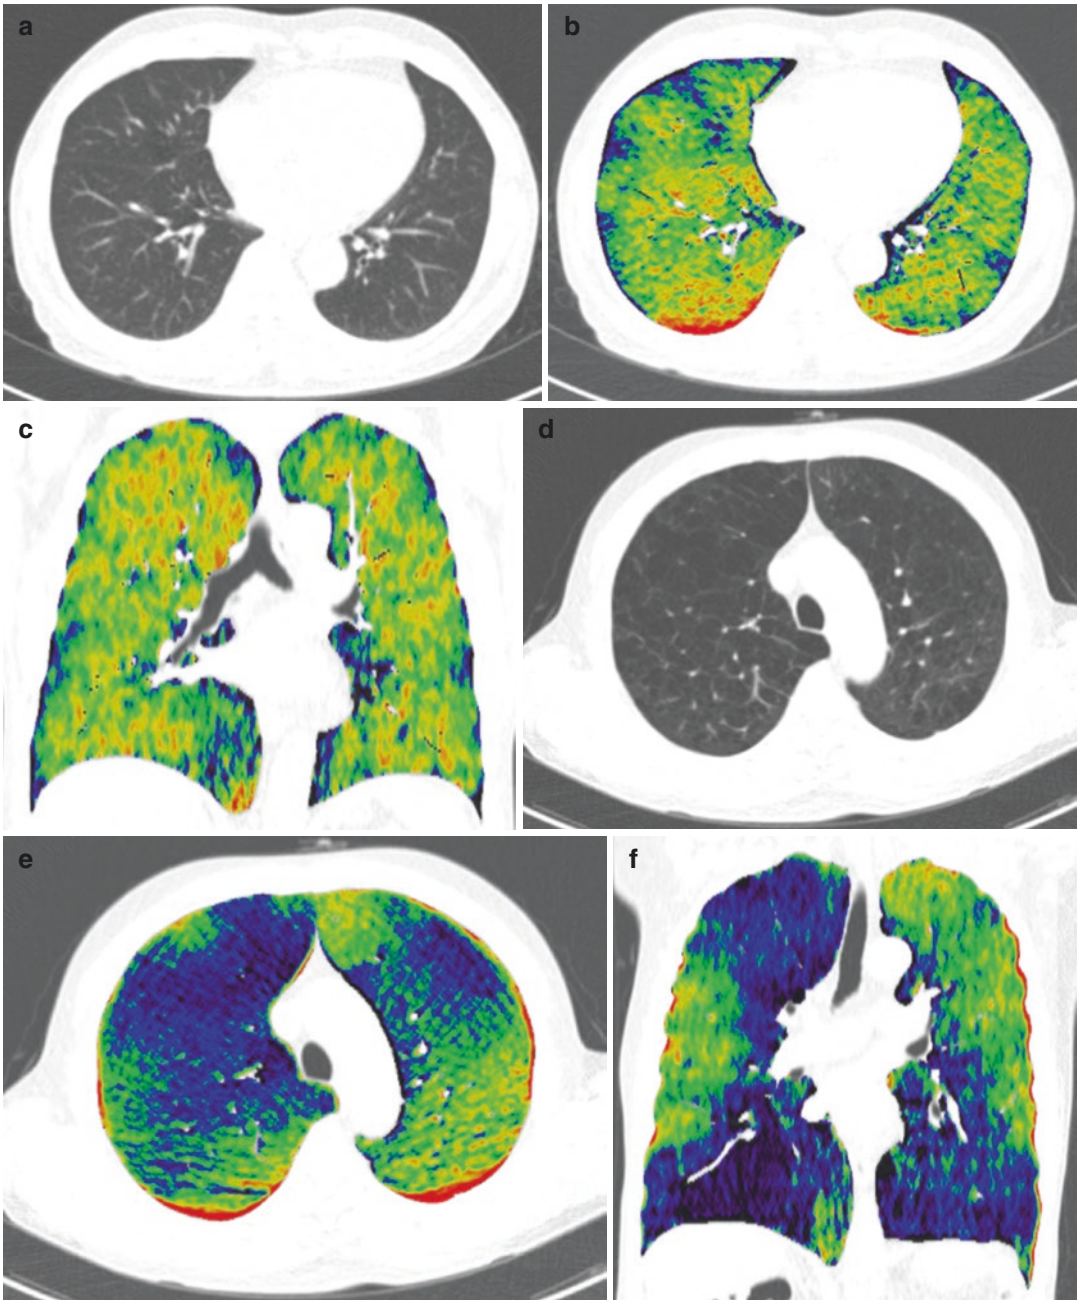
Xenon ventilation image with dual-energy CT in COPD patient. (a–c) Dual-energy CT in COPD patient with mild emphysema. (d–f) Dual-energy CT in COPD patient with severe emphysema. (a, d) Conventional CT image and (b, c, e, f) xenon ventilation map image obtained from xenon ventilation dual-energy CT. On
